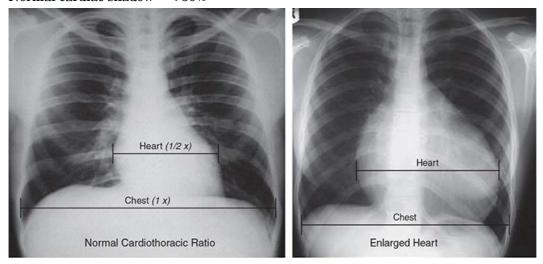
3: Plain radiograph of thorax in PA view. Estimation of the cardiac size in he radiogram of thethorax (Refer text).
